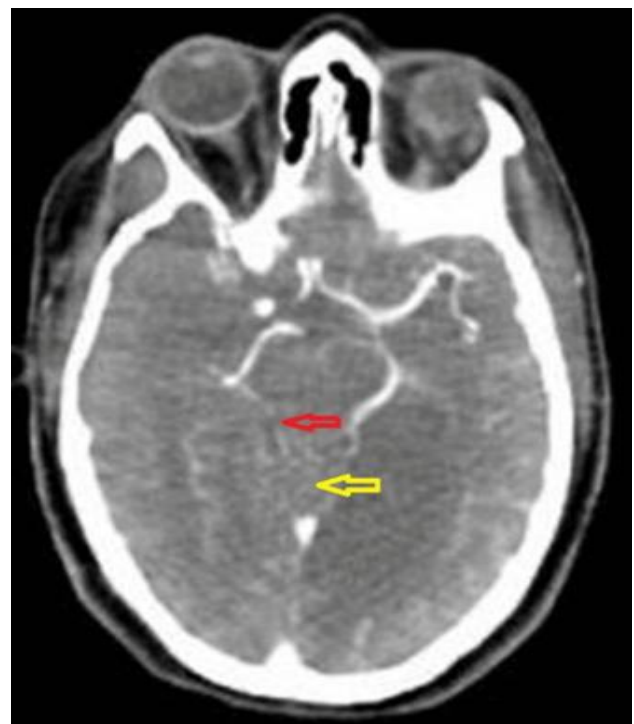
Axial view of CT Angiogram of the carotid and the vertebrobasilar arteries showing non-visualised distal basilar artery (yellow arrow) and P1 segment (pre-communicating segment) of the left PCA (red arrow) representing occlusion.
